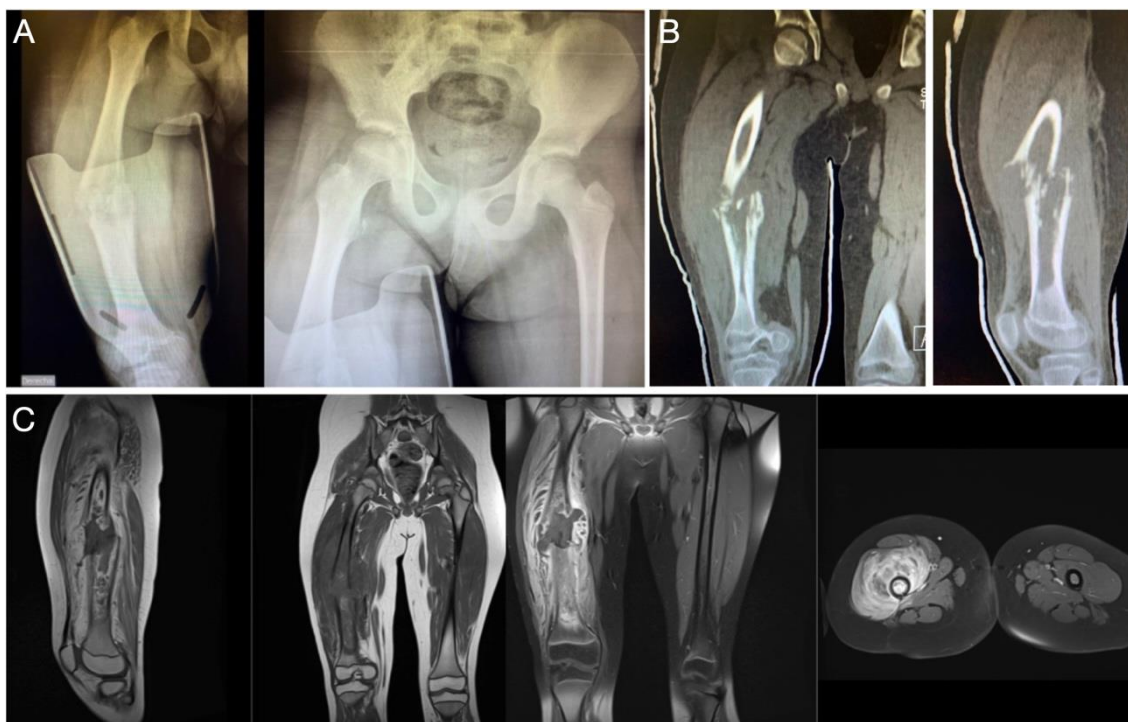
A Rx pathological fracture of the femur. B Coronal and sagittal tomographic reconstruction where cortical destruction is seen. C MRI in sequence T1. Transverse and coronal sections of the femur, where a mid-diaphyseal lesion with a mass of soft tissues is observed and MRI T2 sequence in coronal and axial sections of the femur at the level of the lesion. Femoral lesion is observed, with extension of soft tissues and great perilesional edema.
